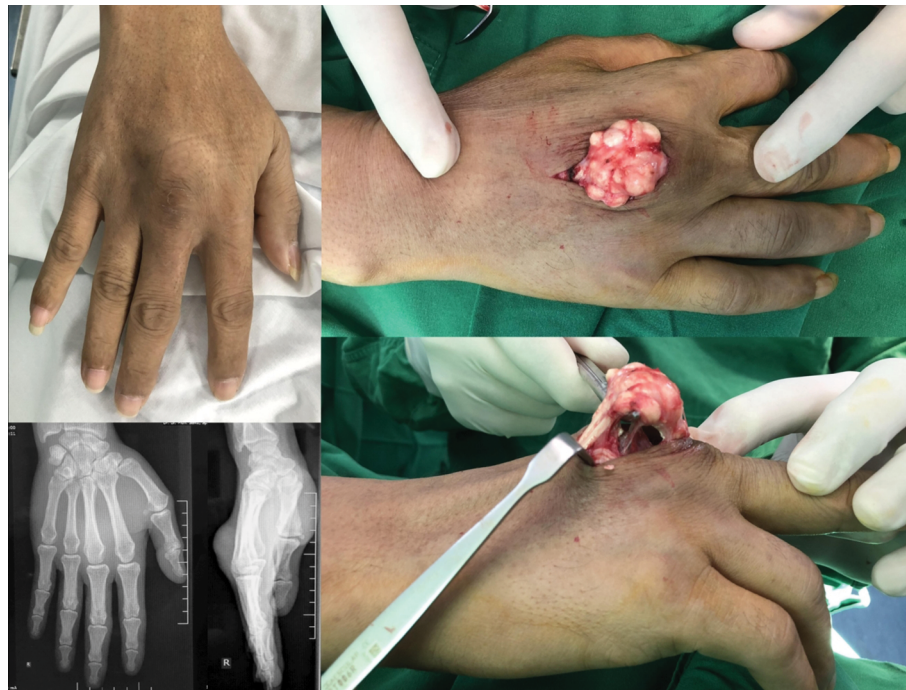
Clinical picture of mass at the dorsal aspect of right hand with soft tissue mass with no apparent findings at the radiograph.
